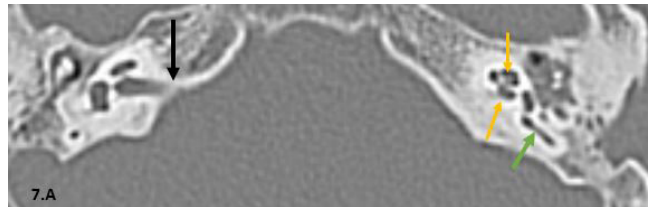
A: Axial CT view, bone window revealed intra cochlear multiple foci of bright hyperdense areas which are suspected to be foci of calcifications (yellow arrows), SCC internal foci of calcifications (green arrow), normal IAC diameter (black arrow).
